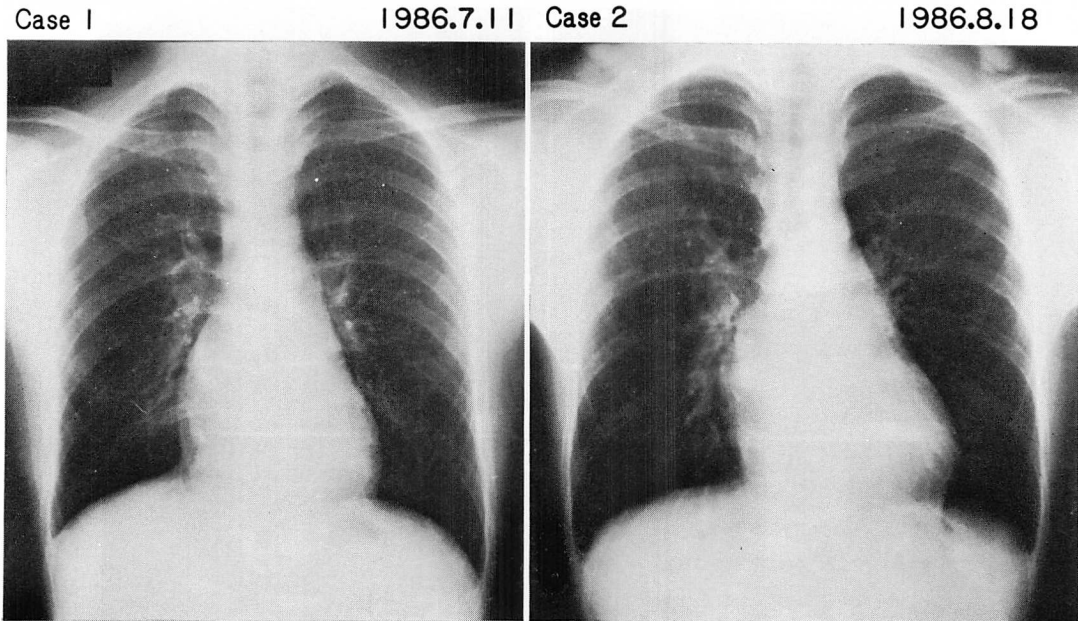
Chest radiographs of Cases 1 and 2.
